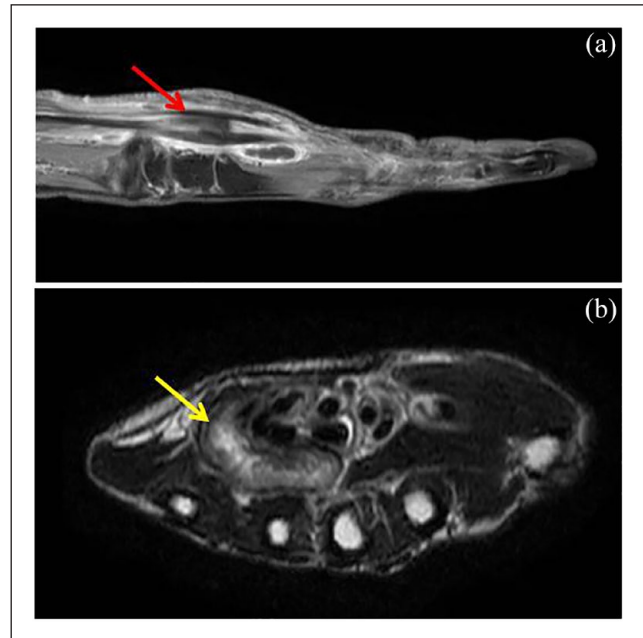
T2 weighted magnetic resonance imaging scan of hand and distal forearm showing synovial thickening with cystic areas over the palmar aspect of hand extending through carpal tunnel into the forearm (a) sagittal section- red arrow, (b) axial section- yellow arrow.
